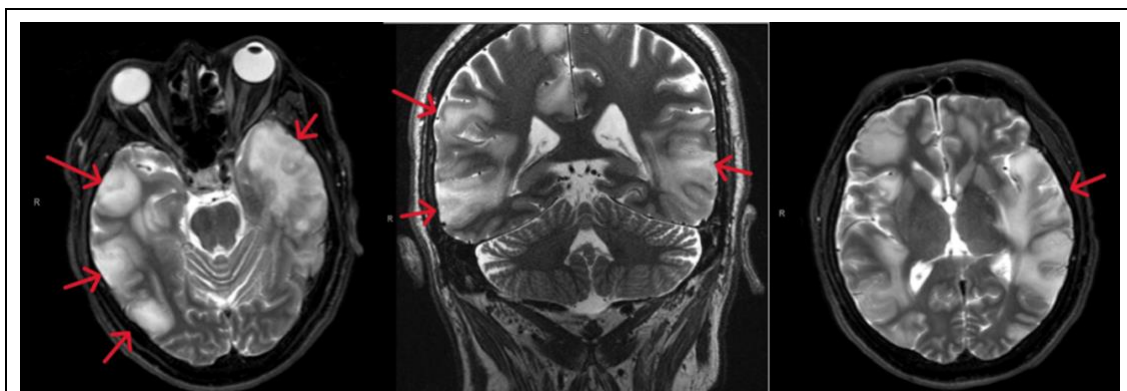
MRI of the brain showing multifocal hyperintense lesions in the frontal, temporal and parietal lobes (Red arrows) with surrounding vasogenic edema observed on T2 sequence. Adapted from Patient.
